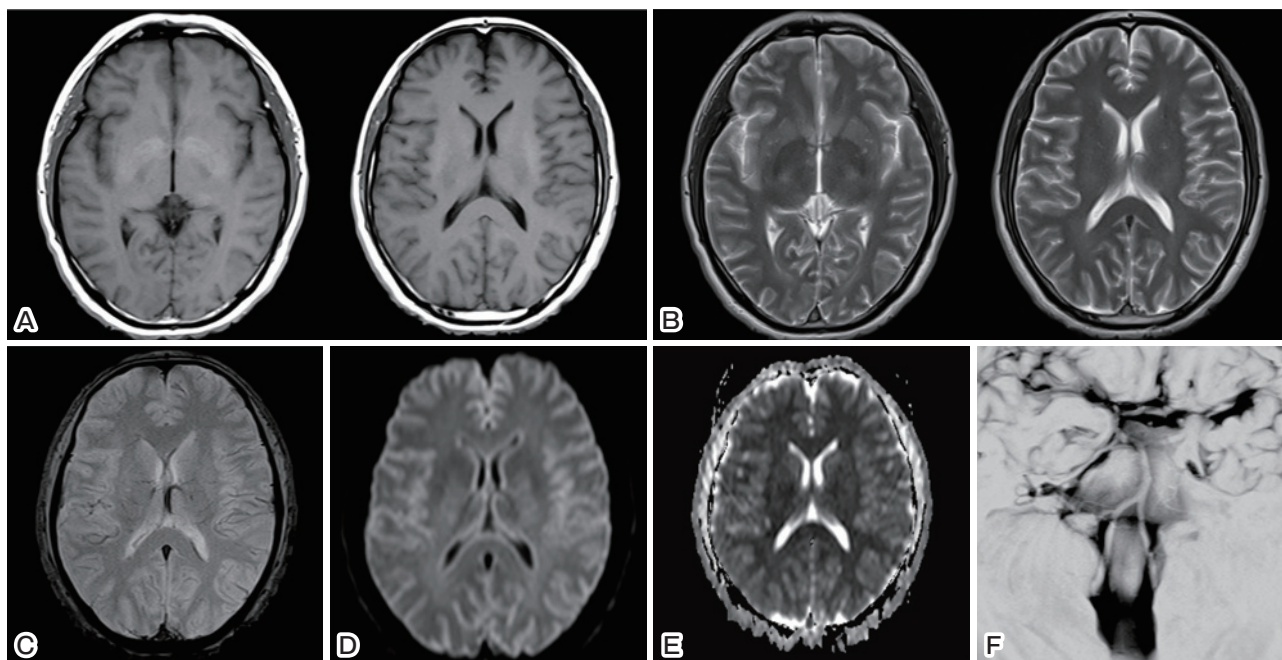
Postmortem magnetic resonance imaging (MRI): T₁-weighted image (T₁WI) of the brain showing a high signal intensity of the globus pallidus and thalamus compared to surrounding white matter (A). T₂-weighted image (T₂WI) showing a low signal intensity of the globus pallidus (B). T₂-star-weighted imaging showing hypointense areas in the globus pallidus (C). Diffusion-weighted imaging showing high-signal-intensity rims along the cerebral cortex and the ventricular wall (D). Apparent diffusion coefficient map showing high-signal-intensity rims along the cerebral cortex (E). Basi-parallel anatomical scanning showed no irregular appearance of the vertebrobasilar artery (F).
